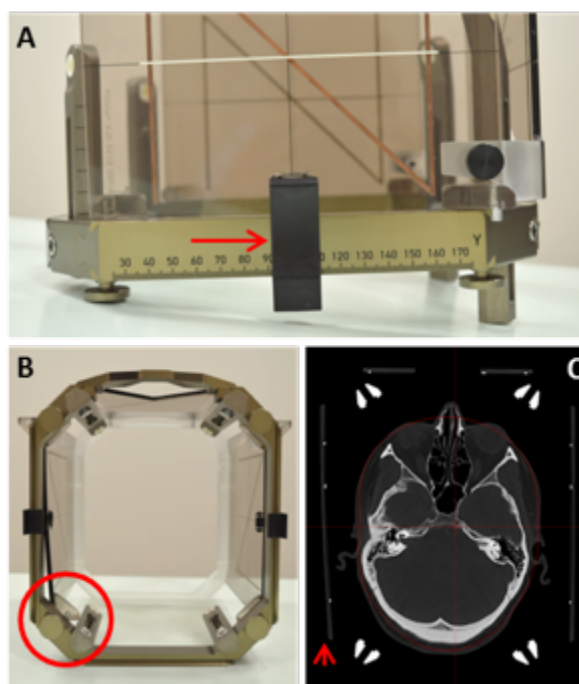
Fiducial indicator box accidentally misplaced at post-GKR CT scan. A. Lateral view of the stereotactic frame with the CT fiducial indicator box in an apparently normal position with the lateral clip adequately secured (red arrow). B. An inferior view of the frame shows the right posterior locating pin of the indicator box displaced towards the midline (red circle) that resulted in an erroneous position of the fiducials in the CT scan (C, arrowhead).
